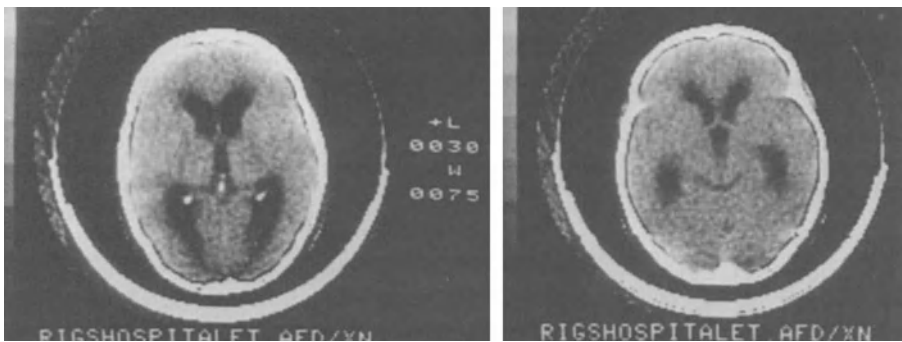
CT of the brain in hydrocephalus developing two weeks after subarachnoid haemorrhage. Note the periventricular hypodensity especially around the frontal horns, indicating transependymal CSF flow (see text)
